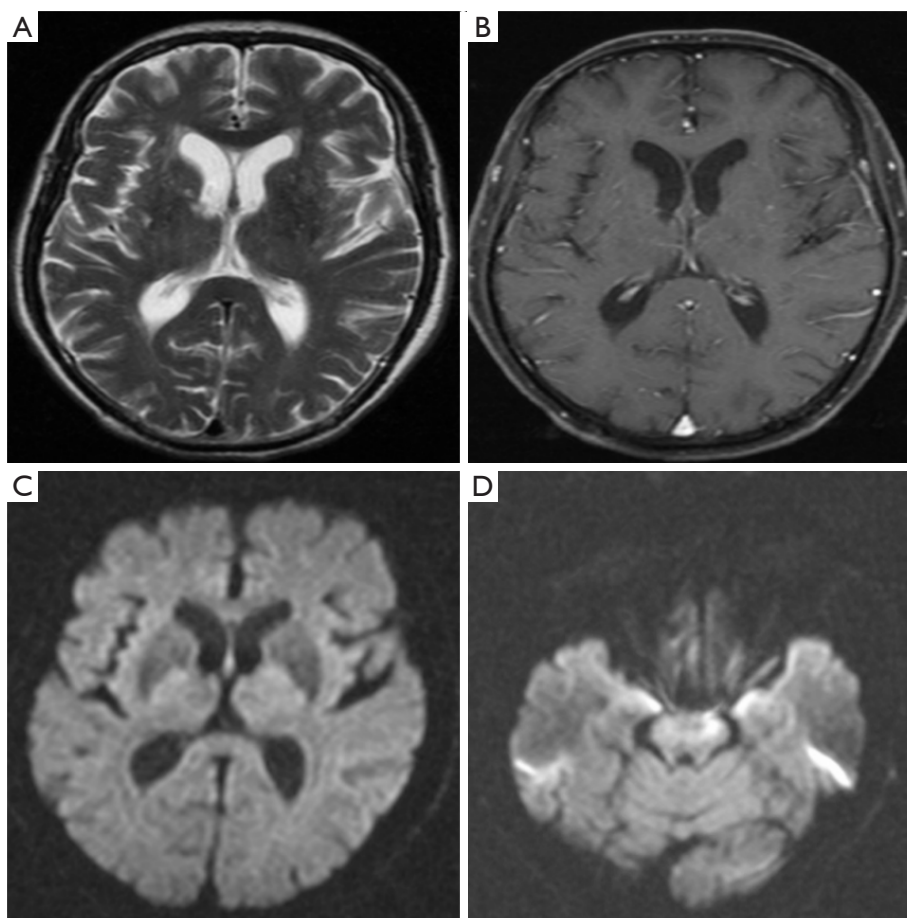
On the 15th day after admission, the 72-year-old male patient underwent a repeat head MRI. (A-D) Multiple lesions in bilateral cerebral hemispheres and brain stem, low signal on T1WI, strong signal on T2WI, and limited diffusion of some brain stem lesions on DWI. MRI, magnetic resonance imaging; T1WI, T1-weighted imaging; T2WI, T2-weighted imaging; DWI, diffusion weighted imaging.
